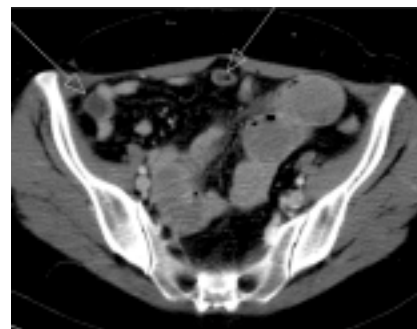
Axial slice of enhanced abdominal CT showing additional bezoars in the small bowel (arrows)
